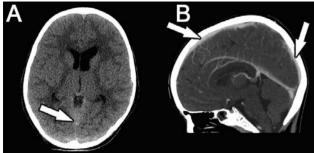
Follow-up axial non-enhanced CT scan of the brain after 72 hours of mechanical thrombectomy and thrombolysis A) demonstrates interval resolution of the hyperdense thrombus within the straight sinus, and after 2 weeks B) demonstrates recanalization of the straight sinus with no residual thrombus.
